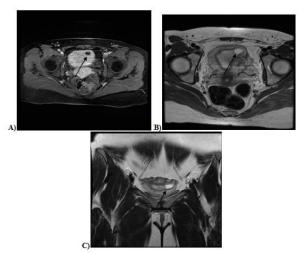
axial view T1 (A) axial view T2 (B) and coronal view T2 (C) of the corneal ectopic pregnancy in MRI.
